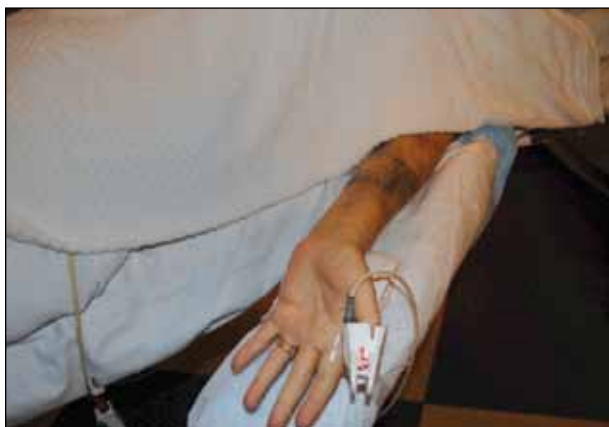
Arm positioned at an acute angle to the table for easier vessel access with ultrasound. Note the towel roll used to support the wrist.
